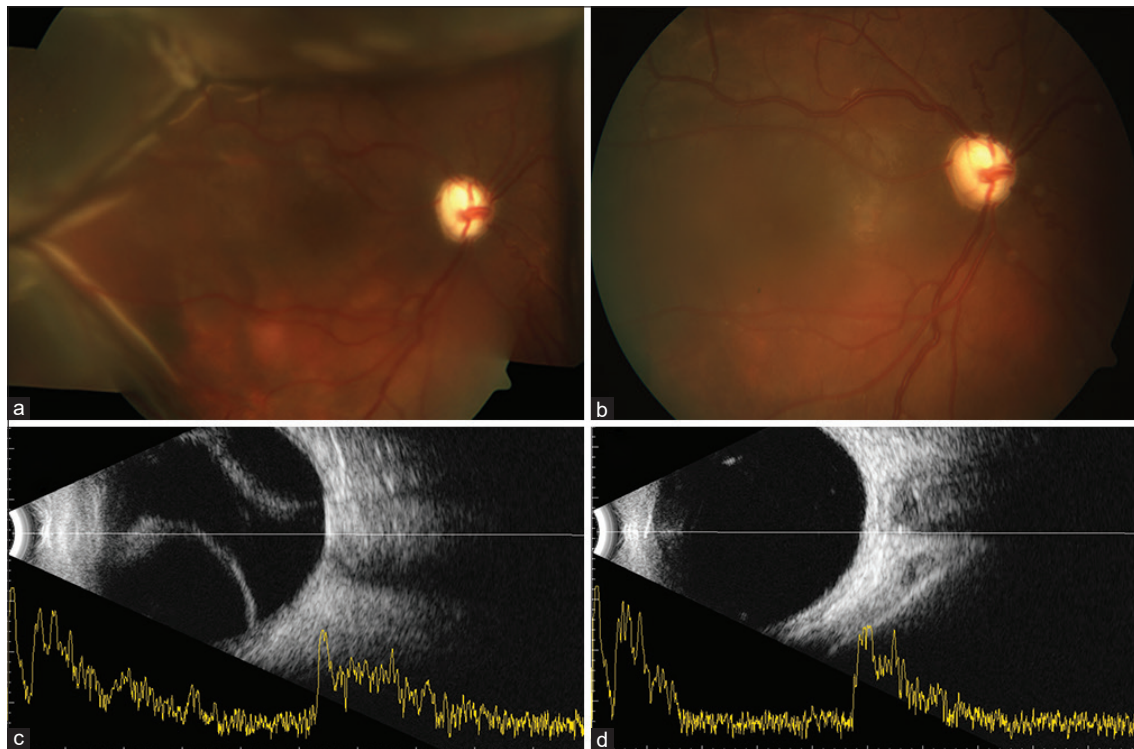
Images of choroidal detachments following trabeculectomy pre and post resolution: (a) Montage color fundus image showing choroidal detachments in all quadrants. (b) Color fundus image following resolution of choroidal detachment (c) Ultrasound B-scan image of an eye with choroidal detachments. (d) Ultrasound B-scan image of the eye following resolution of choroidal detachment
